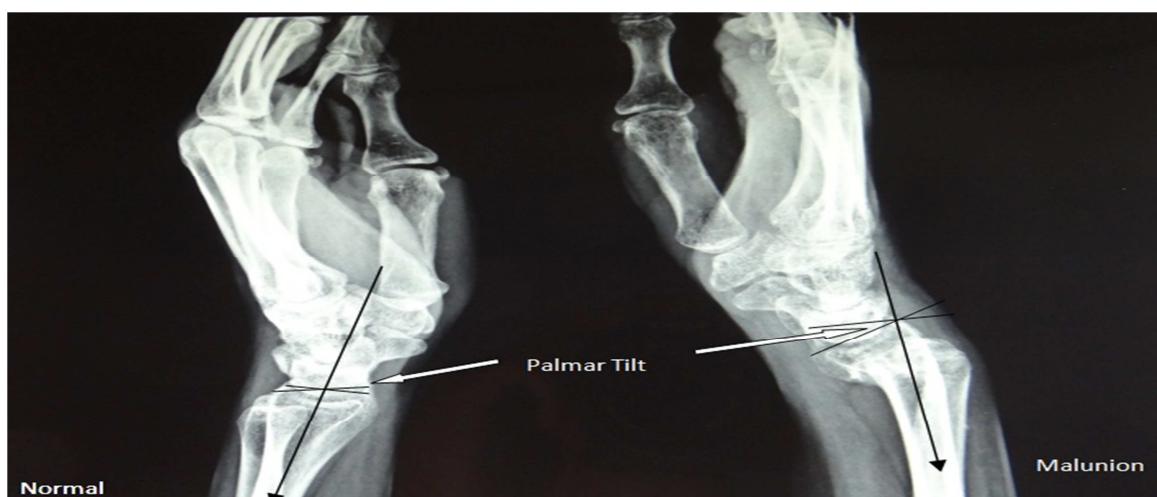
Radiograph of patient hands with wrist (Lateral view).
